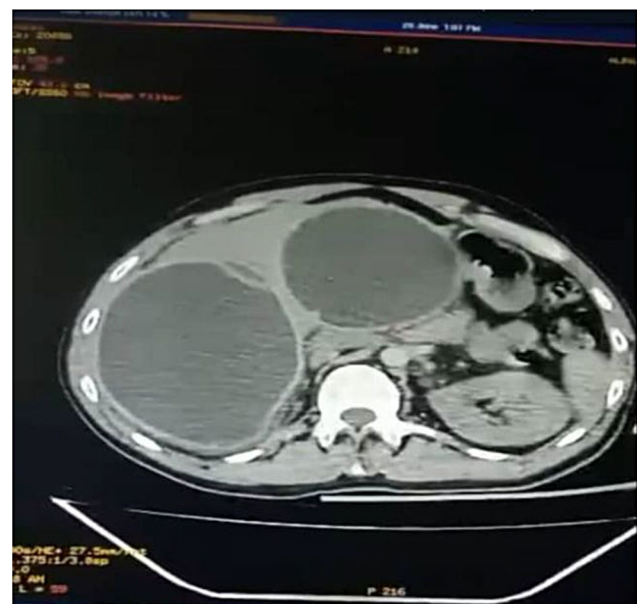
A CT scan image shows the presence of two hydatid cysts in the liver
